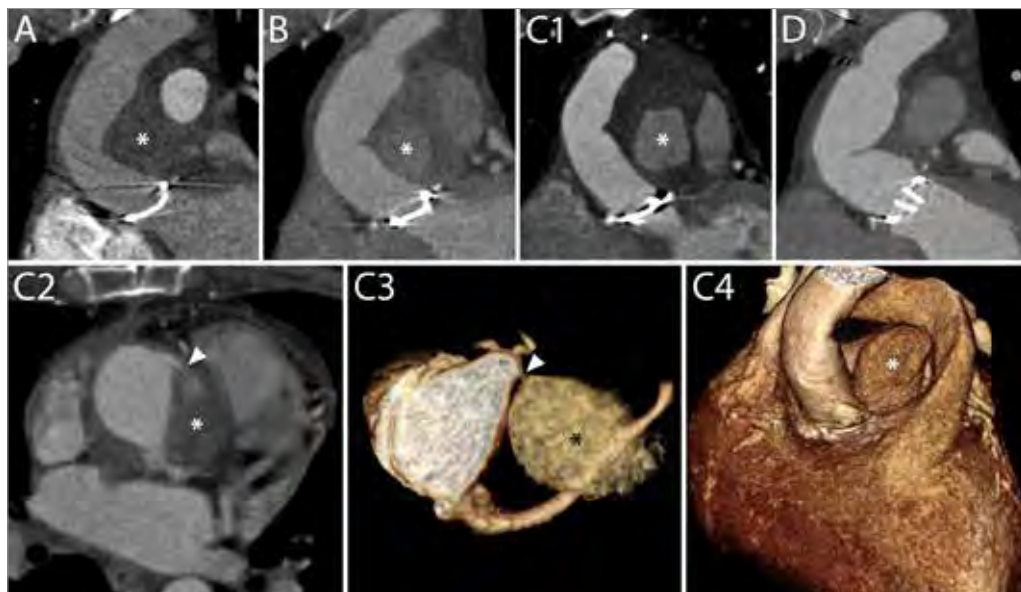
Gradually changing content of a pseudo-aneurysm after Bentall procedure due to contrast leakage from the right coronary anastomosis. A 30-year-old male patient who had undergone a Bentall procedure for acute Type-A aortic dissection three years before, was readmitted to the ER for acute chest pain. During routine yearly follow-up, a collection of fluid had been identified around the aortic root and ascending aorta, which, although its density had increased, had not changed in size (A, B, asterisks). The routine clinical work-up at admission did not show any signs of acute myocardial infarction, but additional CT angiography (C) now showed a significant increase in size of the fluid collection, and clearly demonstrated the presence of contrast material inside (C1, asterisk). A closer evaluation of the axial images (C2) revealed a “puff” of contrast emanating from the anastomosis of the right coronary button (arrowhead), and the additional 3D volume rendering reconstructions highlighted this connection (C3, C4). The pseudo-aneurysm was successfully removed during reoperation, as shown on a postoperative CT scan (D), where-after the leakage was macroscopically confirmed to originate from the anastomosis of the right coronary artery and could successfully be sealed.
